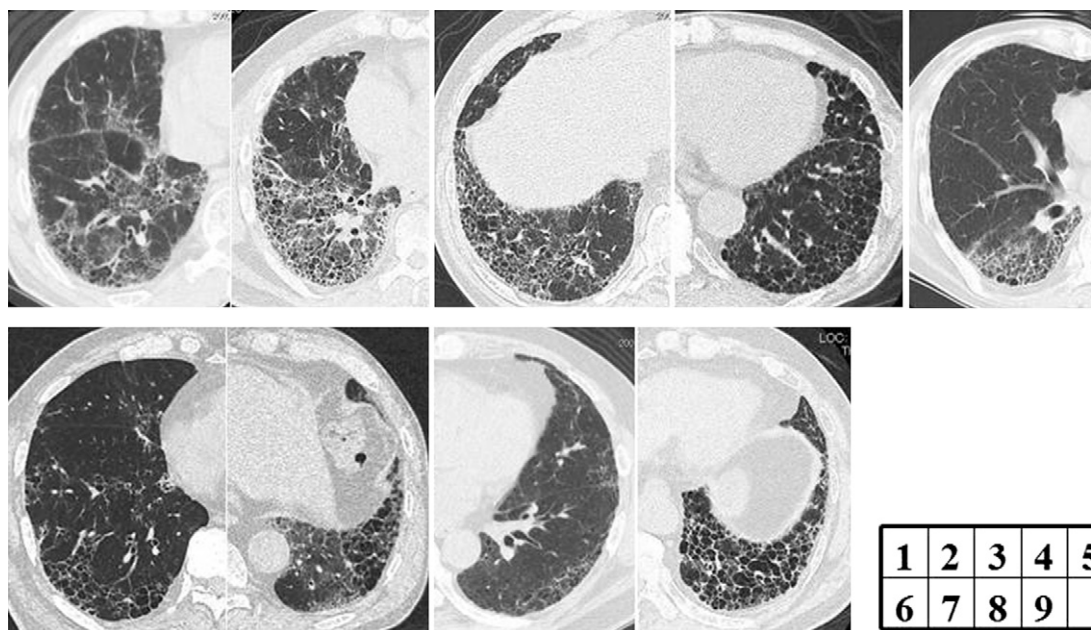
High-resolution computed tomography scans of nine MPO-ANCA-positive cases initially diagnosed with idiopathic pulmonary fibrosis (IPF). A; case 1; B, case 2; C, case 3; D, case 4; E, case 5; F, case 6; G, case 7; H, case 8; I, case 9.
